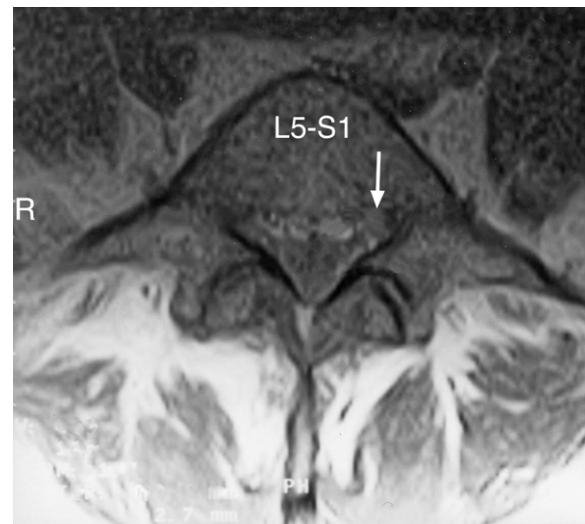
MRI axial T1-weighted image at the L5–S1 level. Note the disc material in the left lateral recess (arrow) compromising the adjacent left nerve root.
